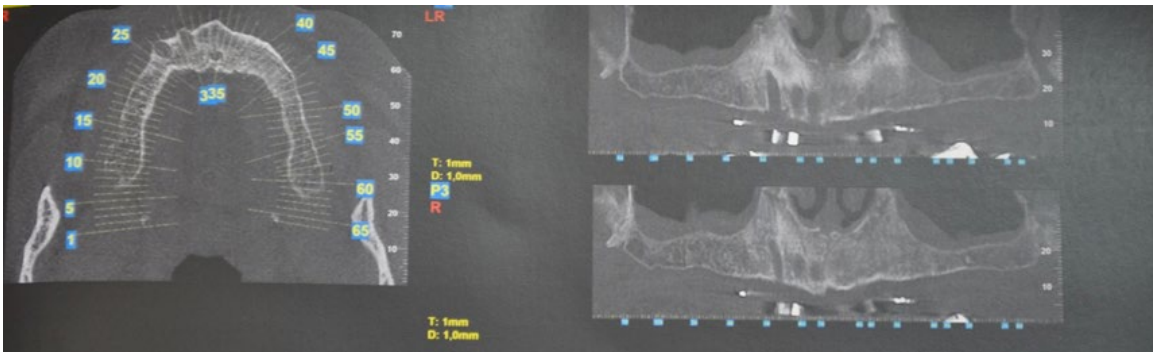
Pre-implant surgery orthopantomography.*
